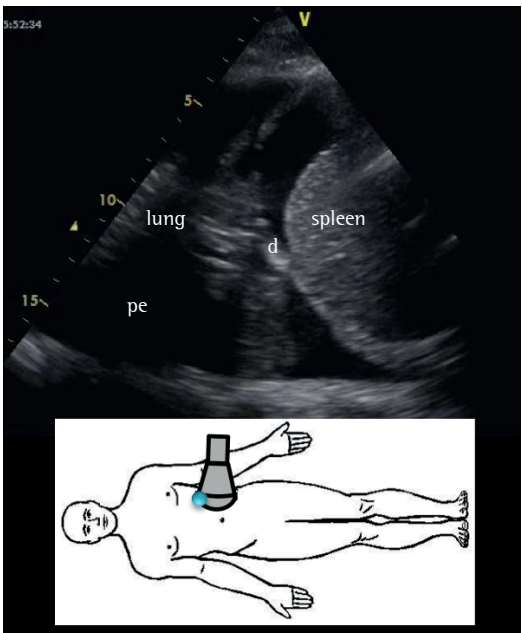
Ultrasound identification of pleural effusion at a specific site (lower image). pe: pleural effusion; d: diaphragm; and c: chest wall.
